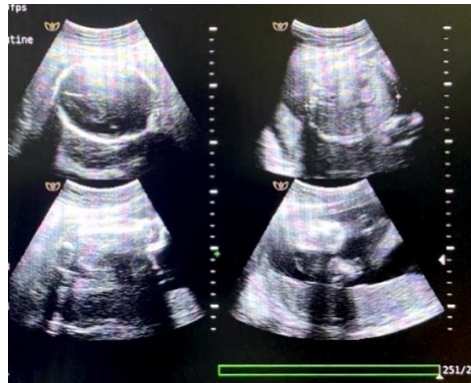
Ultrasonography: operate by obstetrician/gynecologist
